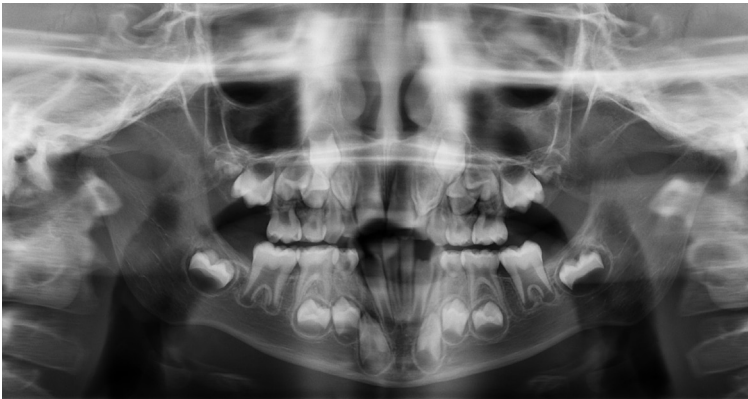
Initial orthopantomogram X-ray
